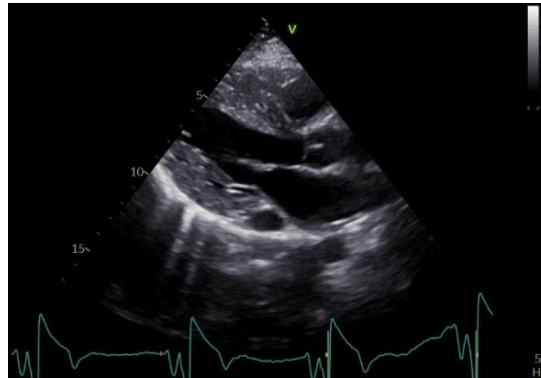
Parasternal long-axis echocardiography view of Non-compaction CMP
